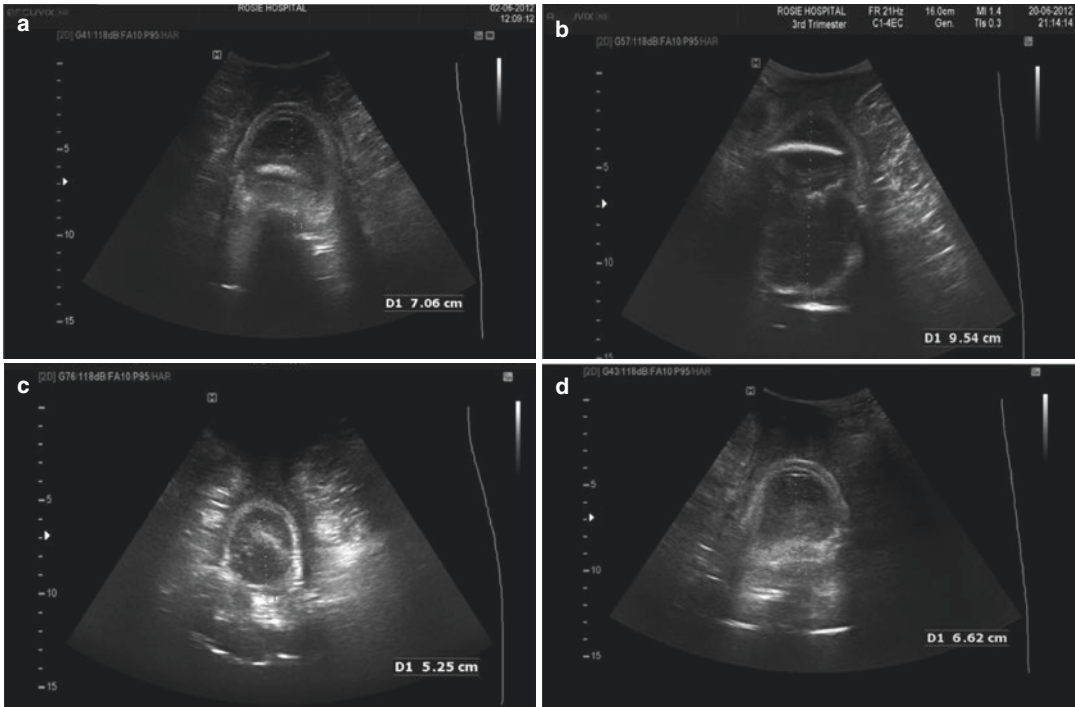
Representative images obtained by two-dimensional (2D) ultrasound at cervical dilatations of (a) 7.1 cm, (b) 9.5 cm, (c) 5.3 cm, and (d) 6.6 cm
